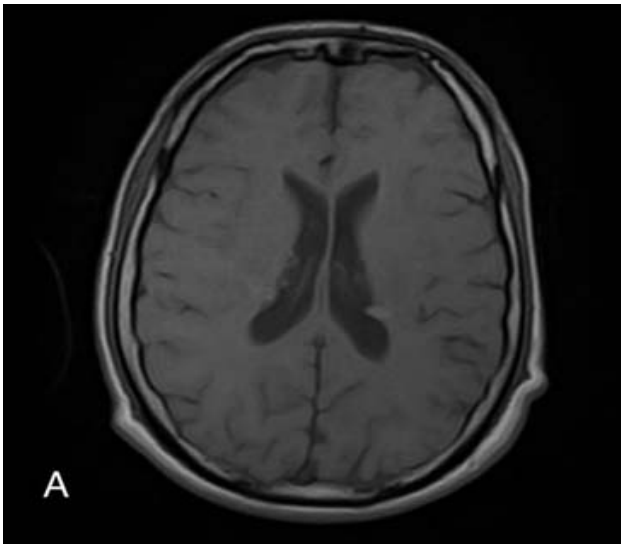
SEN MRI (A: T1, B: T2, C: Flair, D: T1 Post-contrast)
